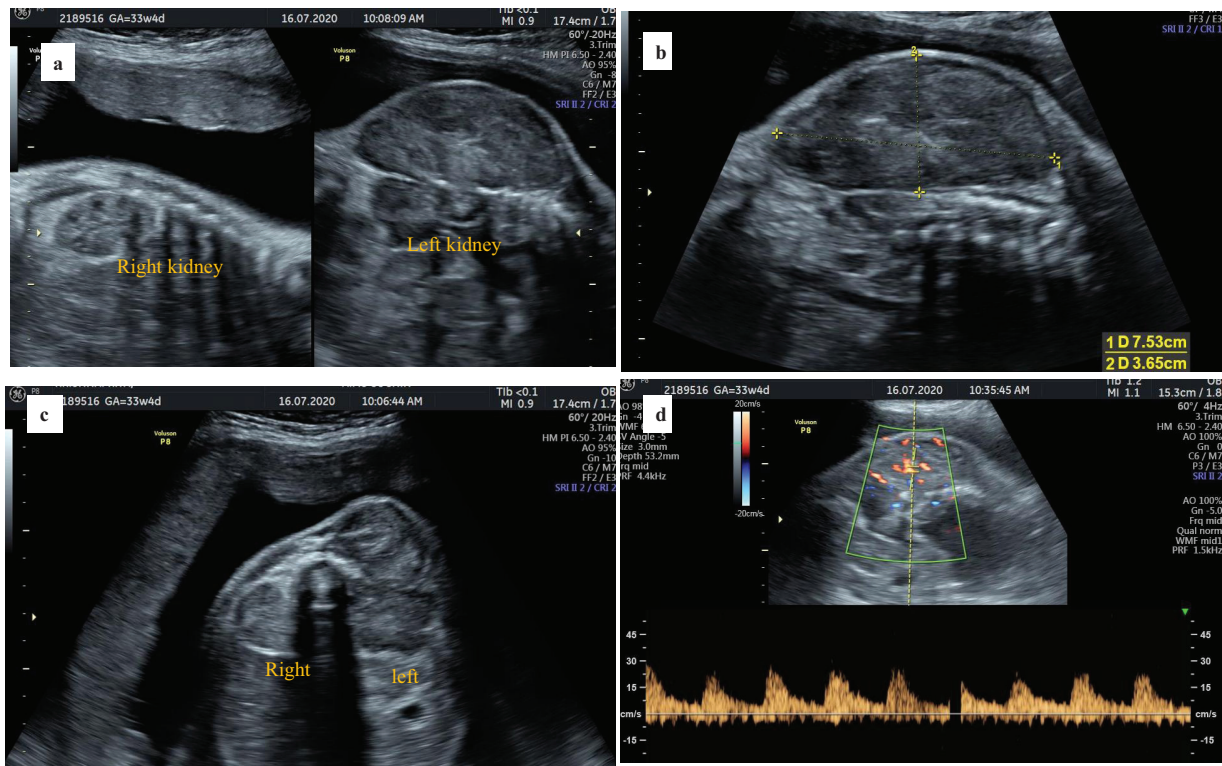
Parasagittal view of the fetal spine with (A) normal appearing right kidney and a well-defined, heterogeneous mass, seen arising from the upper pole of the left kidney extending both intra-abdominally and into subcutaneous plane (the renal parenchyma could not be separately demarcated from the mass). (B) Subcutaneous mass measuring 7.5 × 3.7 cm seen posteriorly. (C) Axial view of the fetal spine with kidneys bilaterally; the posterior subcutaneous extension of the renal mass seen as a bulge on the right side. (D) Color Doppler showing arterial pulsations suggesting tumor vascularity.
